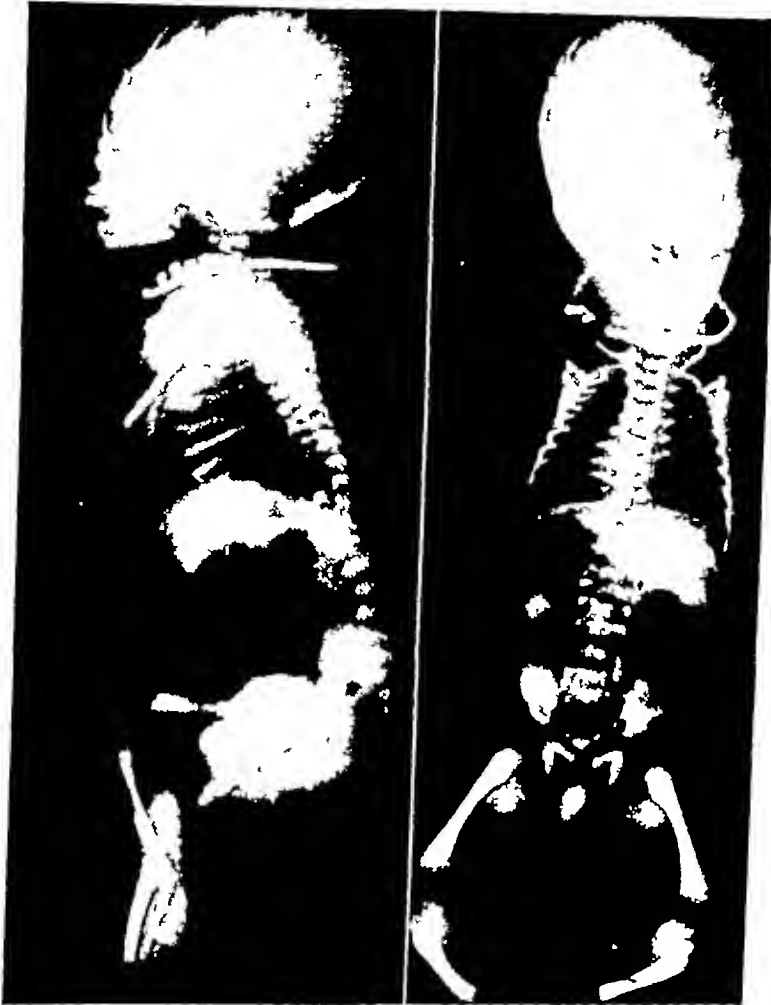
Case 2 Roentgenogram of fetus showing lacuna skull and spina bifida
